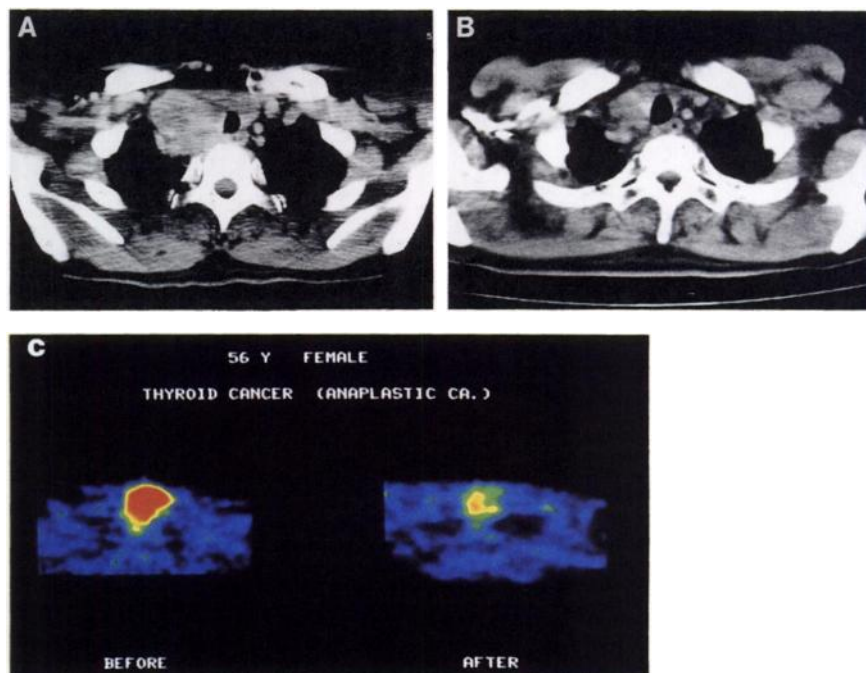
A 56-yr-old female with anaplastic carcinoma of the thyroid. CT before therapy (A) showed a mass density in the right lobe of the thyroid, and high FDG uptake was noted in this lesion (C). After radiation therapy of 51 Gy, the tumor decreased in size (B) and there was decreased FDG uptake (C). There has been no relapse for 9 mo since completion of therapy.
